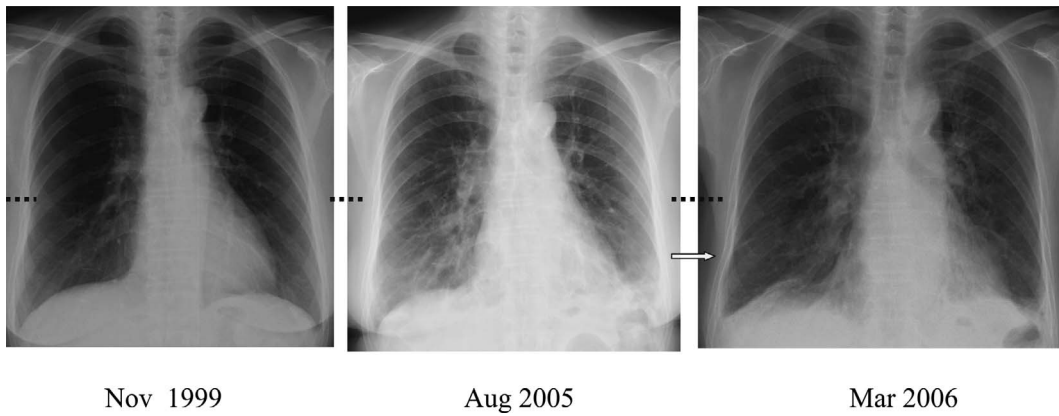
Chest roentgenograms obtained over the clinical course. Reticular shadows are seen in the lower lung fields. The minor fissure in March 2006 (An arrow) is lower than it was in 1999 and 2005 (dotted lines).
